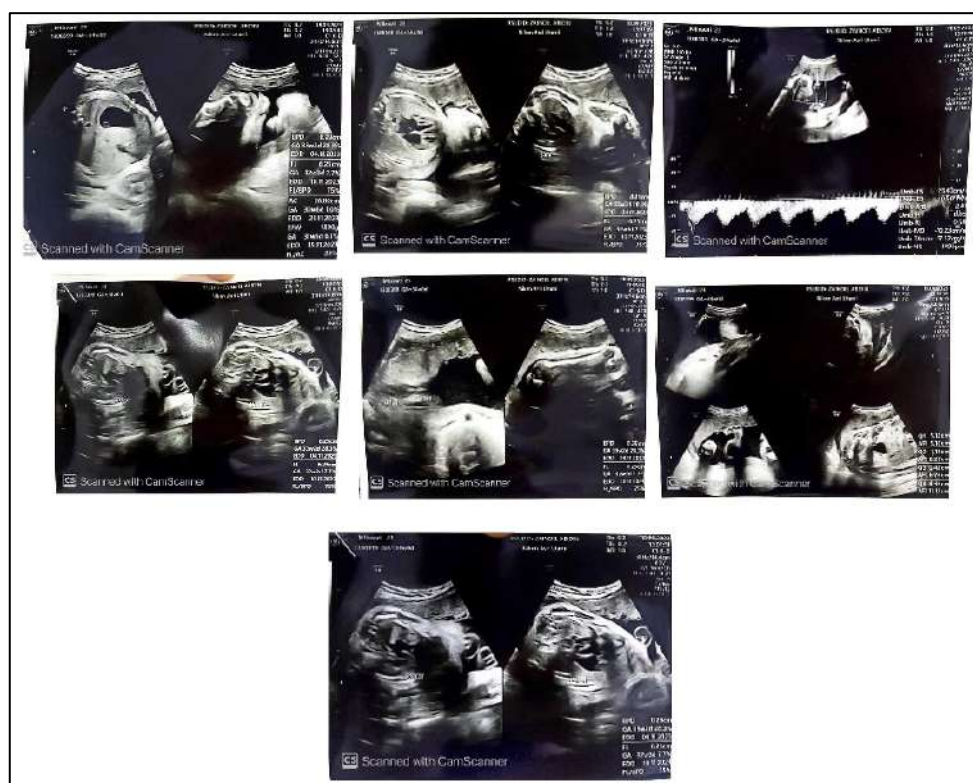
Fetomaternal ultrasound was performed on September 19, 2023.
